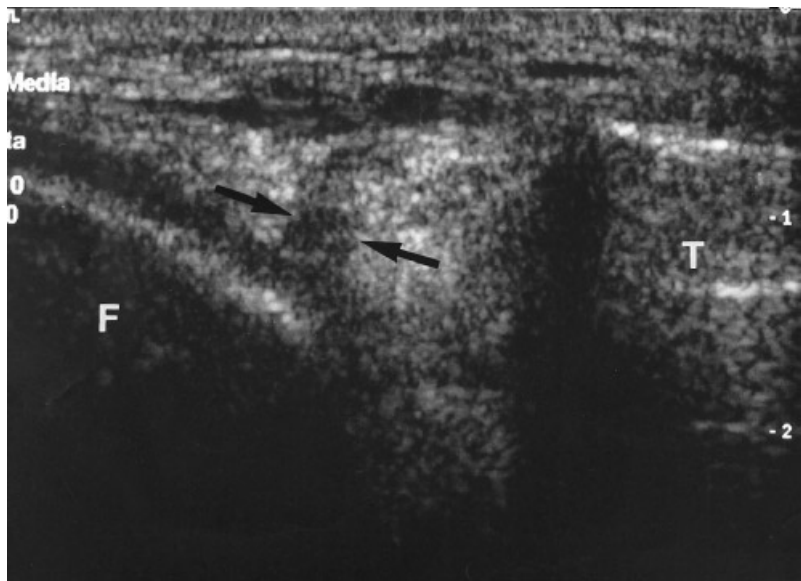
Horizontal tear of the anterior horn of the medial meniscus in a 55-year-old man involved in a traffic accident. Longitudinal sonogram shows a horizontal hypoechoic band (arrows) in the echogenic meniscal triangle. F, medial femoral condyle; T, tibial plateau.
